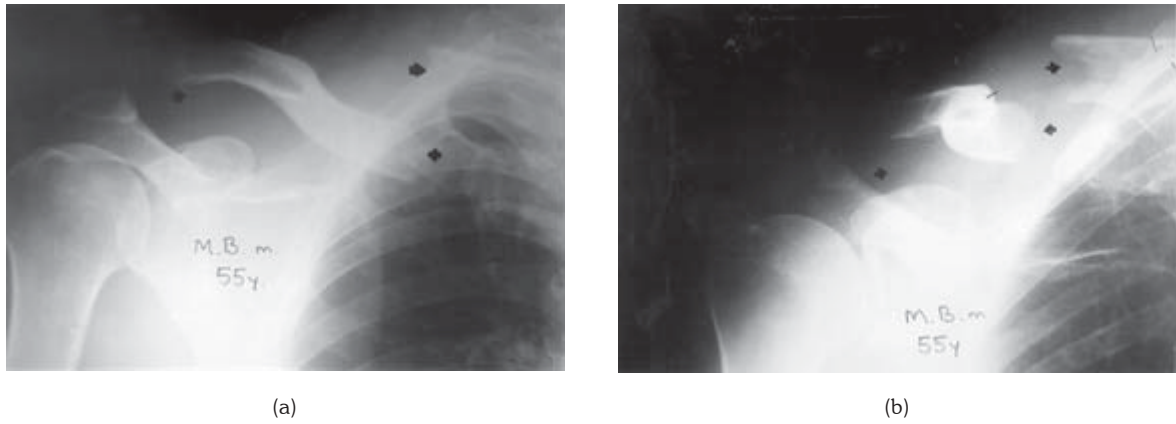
a-b: Radiographic views demonstrating fracture of the medial third of the clavicle and dislocation of the acromioclavicular joint.
